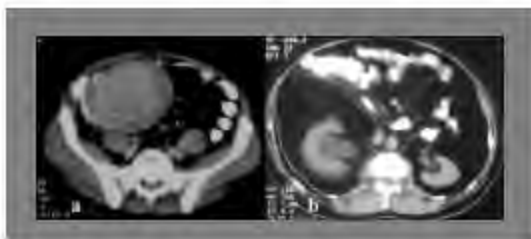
A 72-year-old male patient was admitted to the emergency room with intermittent abdominal pain. Since abdominal radiographs were normal, he was evaluated with CT. (a) At the axial images, a lesion could not be clearly separable which settled in the small intestine anterior wall has been identified and was reported in favor of a tumoral mass. After surgical diagnosis (focal perforation and granulation due to fishbone) with the adjustment of slice thickness, window levels of the previous CT sections (b) hyperdense linear, foreign body could be visualized in the pseudomass lesion (arrows in a and b).
